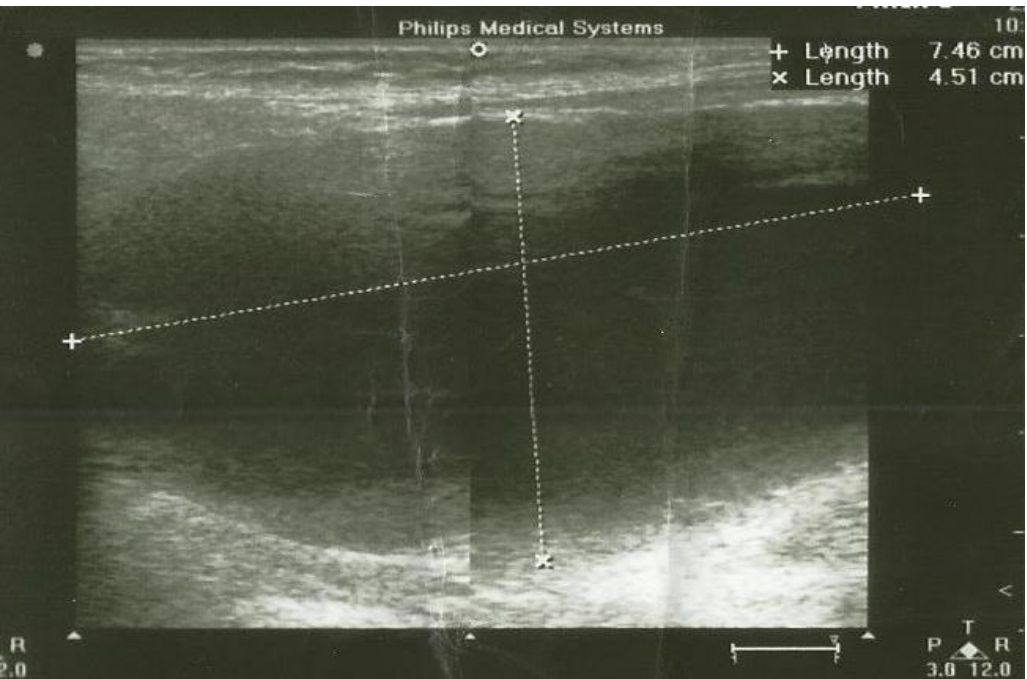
Sonography of a 63 years old female shows a cystic lesion in posterior triangle of the neck.
